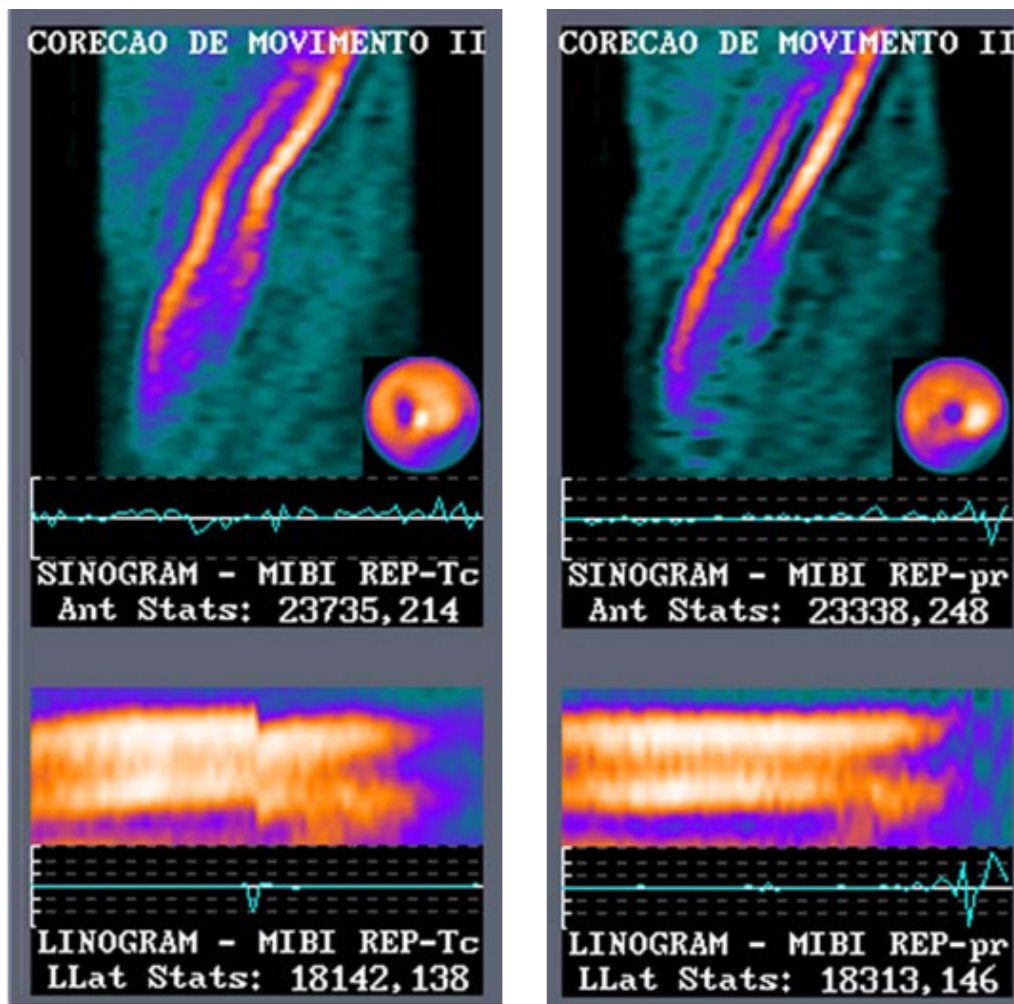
A rest myocardial perfusion study: (left) sinogram and linogram showing patient movement during the SPECT acquisition which, before correction, presents with a perfusion deficit in the patients' anterior wall; (right) after motion correction of the sinogram data, the sinogram and linogram now appears uninterrupted and the perfusion deficit moves to the apex.
